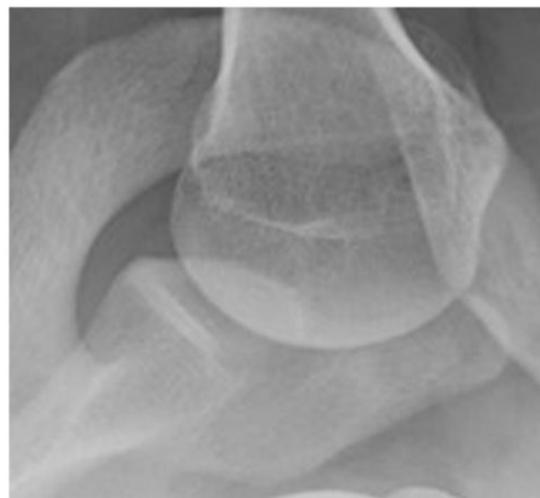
Lateral radiograph of left shoulder demonstrating glenoid bone loss.
